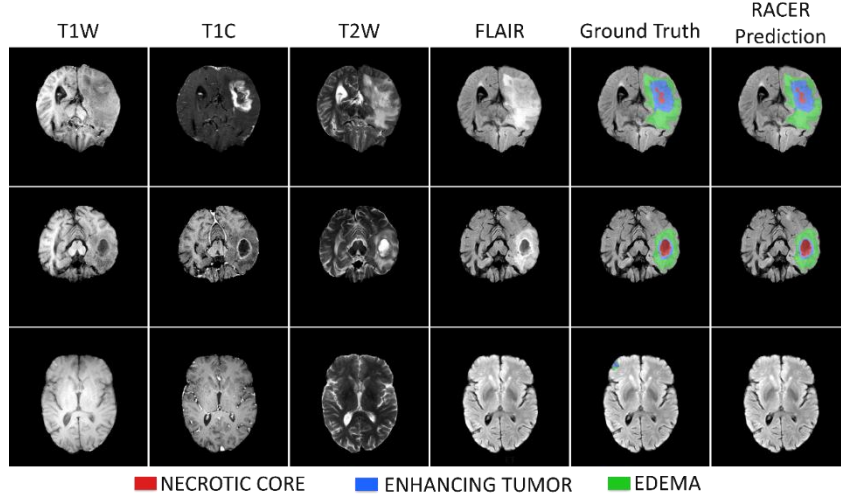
Internal held-out cases with reference and RACER prediction overlaid on FLAIR. Row 1, row 2 and row 3 show a strong, an average and a weaker case, respectively.
